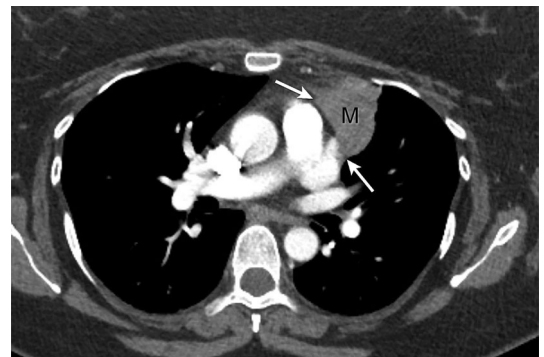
T2 tumor. Contrast-enhanced axial CT of the chest demonstrates a 4-cm mass (M) abutting the pericardium (arrows). At surgery, a thymic carcinoma involving the perithymic adipose tissue and pericardium was detected, consistent with a T2 tumor.
